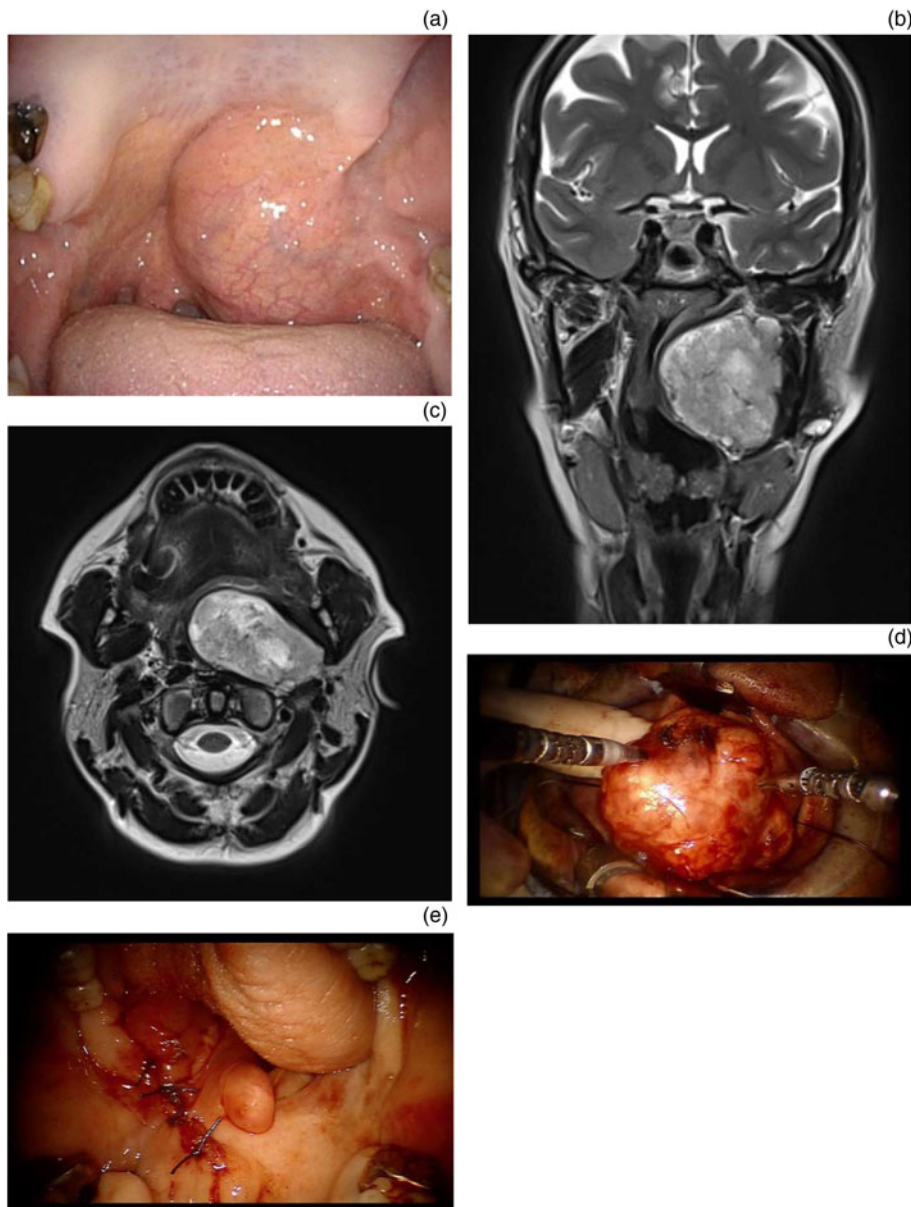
Pleomorphic adenoma of the left parapharyngeal space in a 52-year-old woman. (a) Clinical examination showing an oropharyngeal bulge, (b) pre-operative coronal plane magnetic resonance imaging (MRI) scan, (c) pre-operative axial plane MRI scan showing a 5 cm mass occupying the parapharyngeal space, (d) intra-operative view of final dissection and delivery of the tumour with the finger and (e) intra-operative view of primary closure of the oropharynx.
